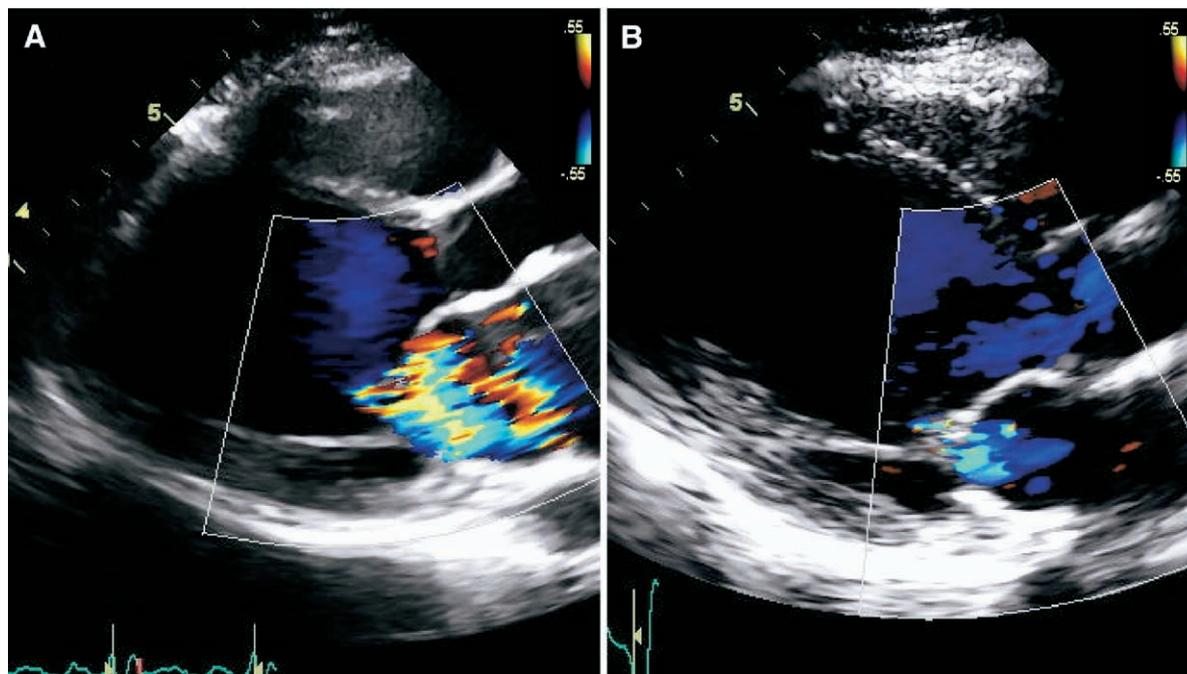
Parasternal long-axis view demonstrating reduction in mitral regurgitation in patient from before (A) to day after (B) resynchronization therapy.
